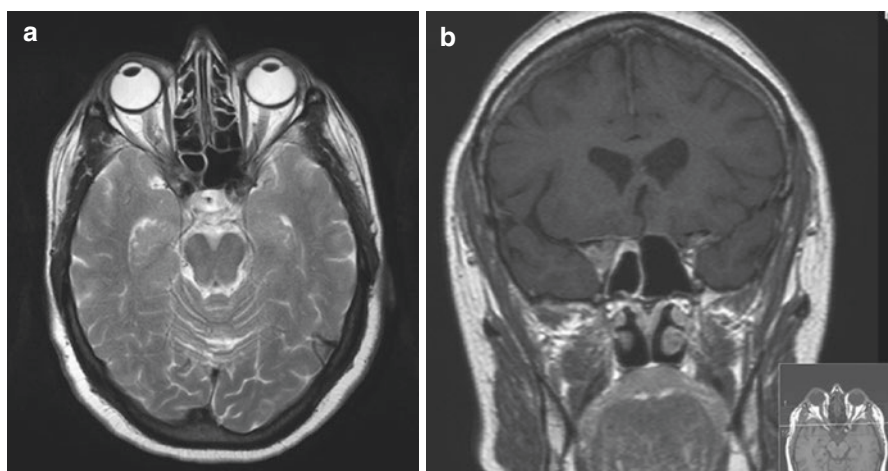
T2 weighted axial (a) and T1 weighted enhanced coronal (b) MR images of orbits showing a right orbital apex mass which surrounds the optic nerve (Reproduced with permission from O'Toole et al. [1])
